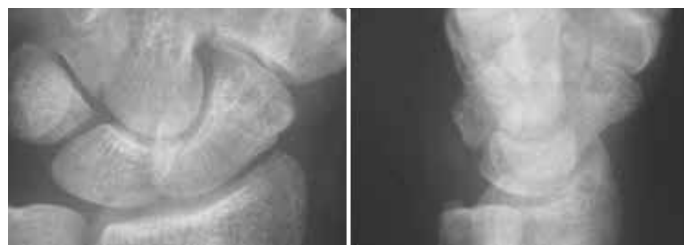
Radiographic examination after follow-up of 15 months, showing absence of lesions.
